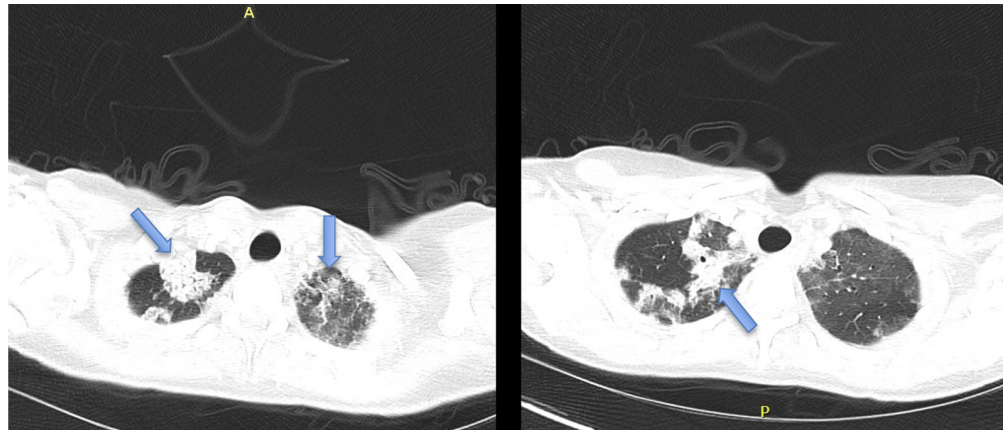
Computerised tomography (CT) thorax demonstrating multifocal peri-bronchial consolidation (arrows), consistent with an organising pneumonia. A, anterior; P, posterior.
